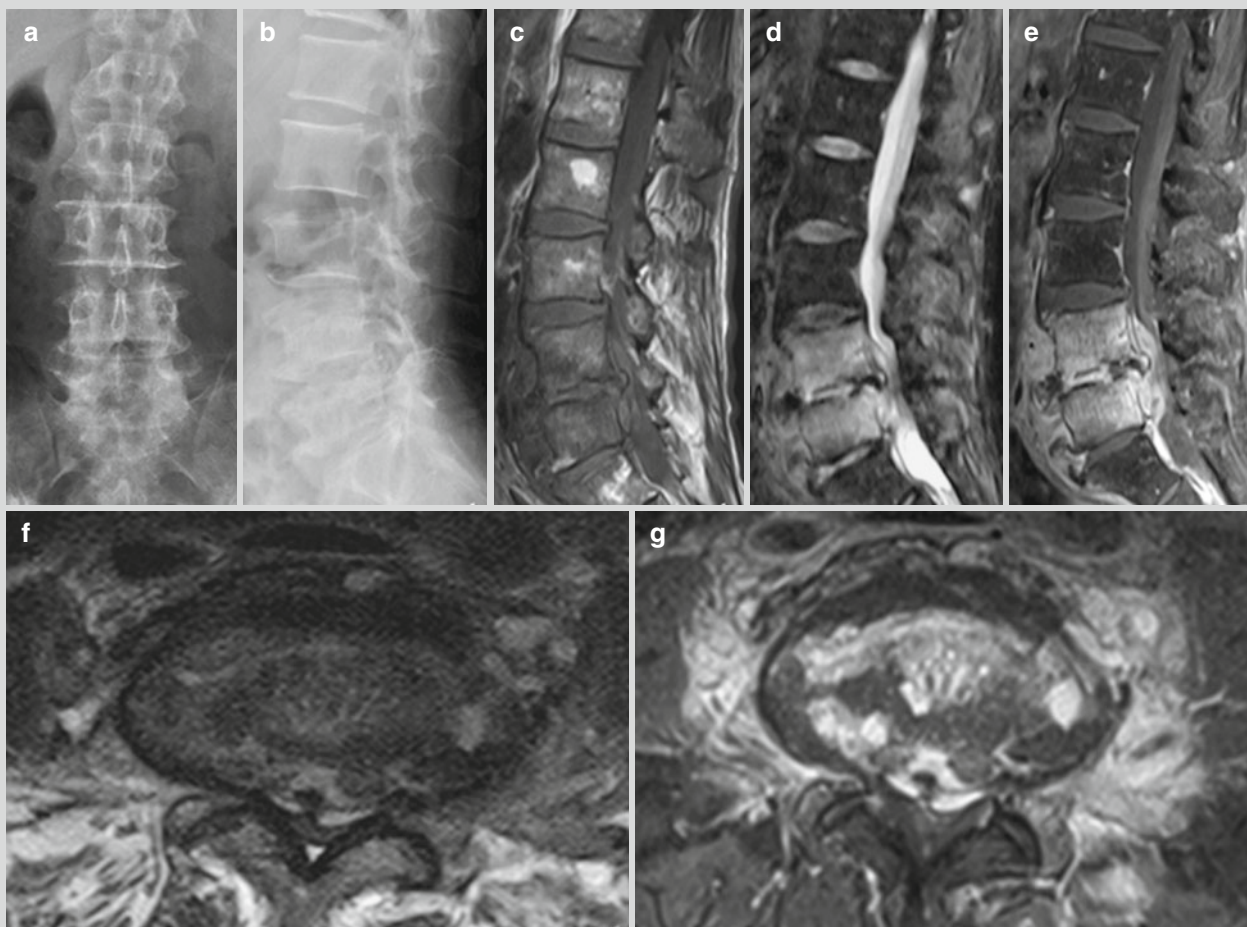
Brucellar spondylitis. (a, b) Lateral and anterior-posterior imaging demonstrates intact sequence of lumbar vertebrae, obvious osteoproliferation at L2–L5 and bone destruction at the posterior margin of L5. (c, d, f) MR imaging demonstrates intact sequence of the lumbar vertebrae, diffuse slightly long T1 and long T2 signals at L4 and L5, no involvement of the appendices, obvious osteoproliferation at the L4 and L5, focalized destruction of the inferior end plate of the L4 and superior end plate of L5. The intervertebral space is demonstrated to be narrowed at L4–L5 and L5–S1, with internal long T2 signal and disk protrusion. Its posterior dural sac is
